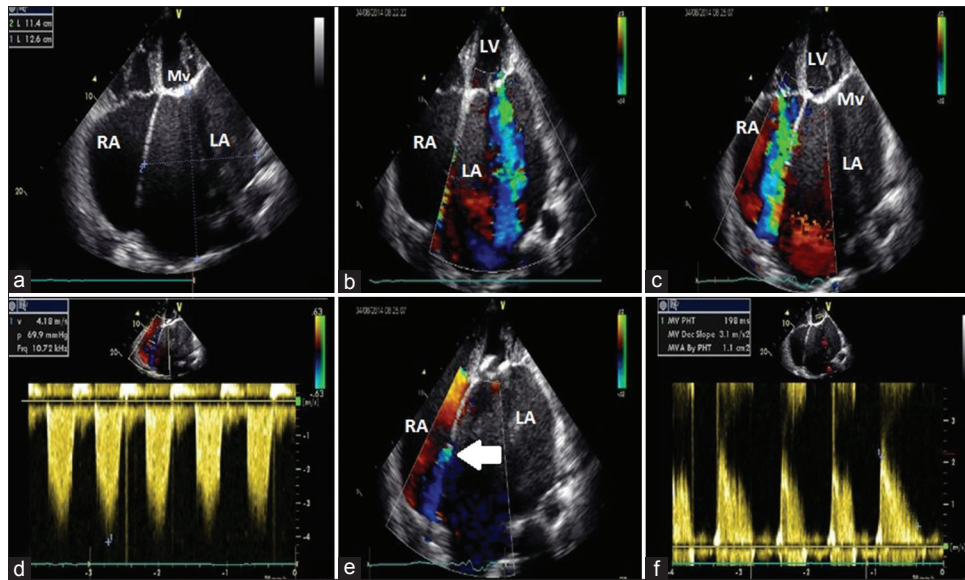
Transthoracic echocardiography apical 4-chamber view image showing calcified and thickened mitral valve with giant left atrium (a), severe mitral regurgitation (b), severe eccentric tricuspid regurgitation with a pulmonary systolic pressure of 80 mmHg (c and d) and mild left-to-right shunting across an ostium secundum atrial septal defect (e, arrow) and mitral valve area was 1.1 cm² according to the pressure half-time method (f). RA: Right atrium, LA: Left atrium, LV: Left ventricle, MV: Mitral valve
